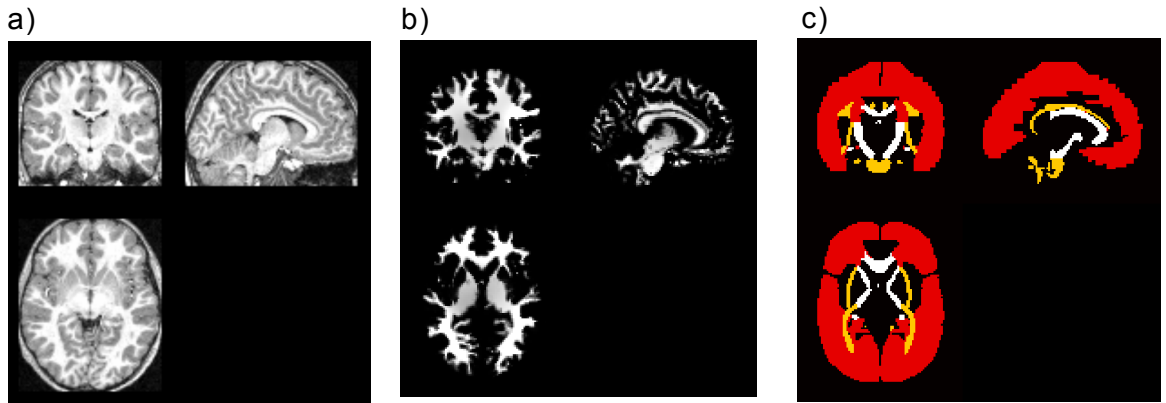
Coronal, sagittal and axial views of a) T1-weighted anatomical image, b) white matter probability map c) compartmental ROIs before intersection with white matter probability mask. Radiate white matter is in red, bridging in white and sagittal in yellow.
